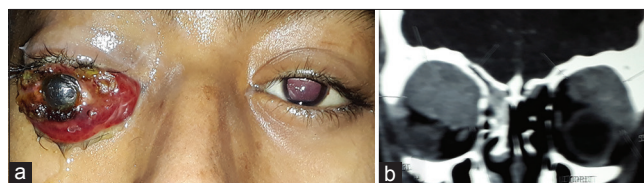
(a) External photograph showing gross proptosis of the right eye with severe exposure keratopathy, and (b) computed tomography scan of the orbit, coronal cuts, showing bilateral isodense orbital mass in the superior extraconal space
